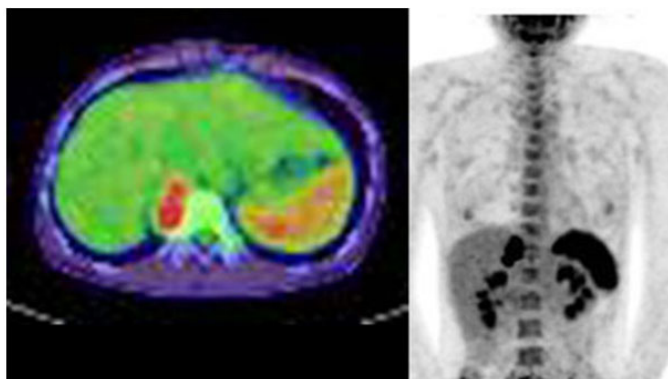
Positron-emission tomography in case 2. Abnormal hyper uptake ($SUV_{max} = 11.0 [60 \text{ min}]/15.9 [120 \text{ min}]$) is seen in the tumor and the spleen.
